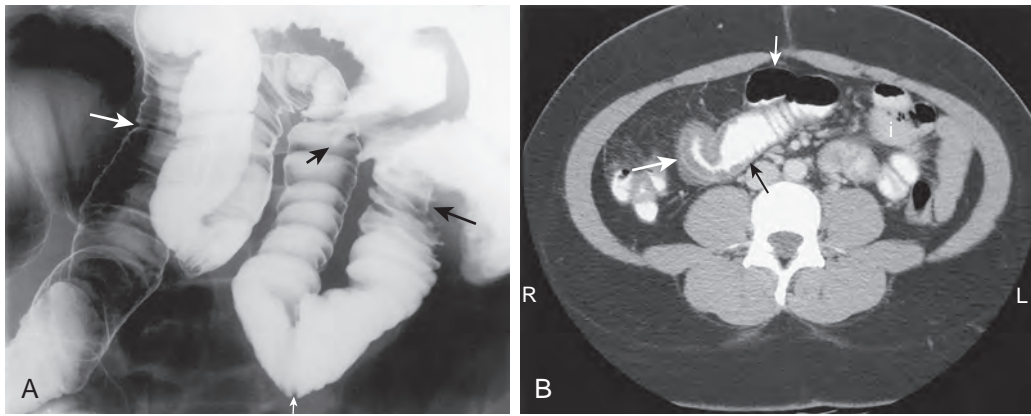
Long segment of radiation enteropathy demonstrated by small bowel follow-through. A. Spot image shows abnormal loops of ileum (between *long arrows*). The folds are thickened but retain their normal orientation perpendicular to the longitudinal axis of the small bowel. Two areas of angulation (*short arrow*) are identified as a result of radiation serositis. No obstruction was seen. B. CT scan shows marked wall thickening (*long white arrow*) in a loop of ileum. Mild fold thickening is seen more proximally (*black arrow*). Note the normal wall thickness (*short white arrow*) in small bowel proximal to the diseased segment. Little anatomic detail is available in some loops (i).
